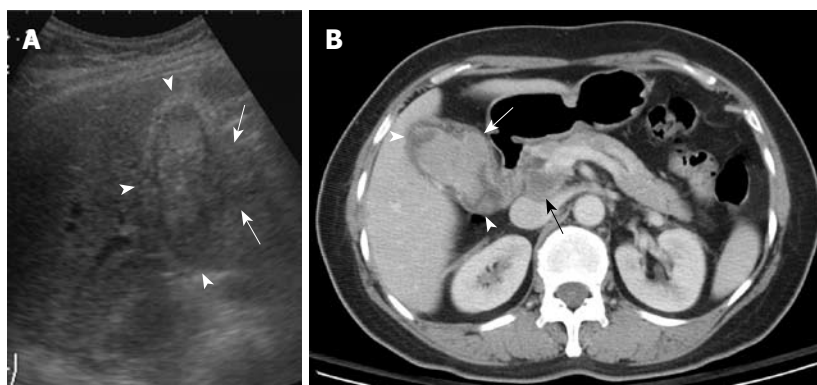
A 78-year-old woman with right upper abdominal pain and progressive jaundice for 2 mo. A: US showed an intraluminal heteroechoic mass that occupied nearly the whole gallbladder (arrowheads), with focal extraluminal invasion (arrows); B: Contrast-enhanced CT showed a large lobulated mass within the gallbladder (arrowheads), with extracholecystic invasion (white arrow) and hepatoduodenal ligament lymph node metastasis (black arrow).
